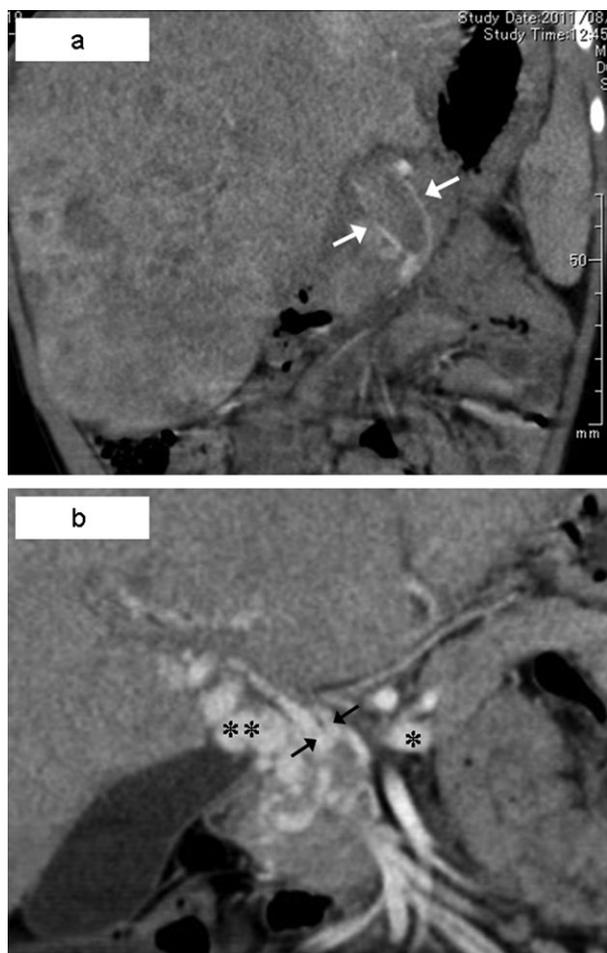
Abbreviations: FDG, F<sup>18</sup>-fluoro-2-deoxy-D-glucose; HBL, hepatoblastoma; LDLT, living-donor liver transplantation; PET, positron emission tomography; POST-TEXT, post-treatment extent of disease; PRETEXT, pretreatment extent of disease; PV, portal vein.; PVTT, portal vein tumor thrombosis; SMV, superior mesenteric vein; SpV, splenic vein.
